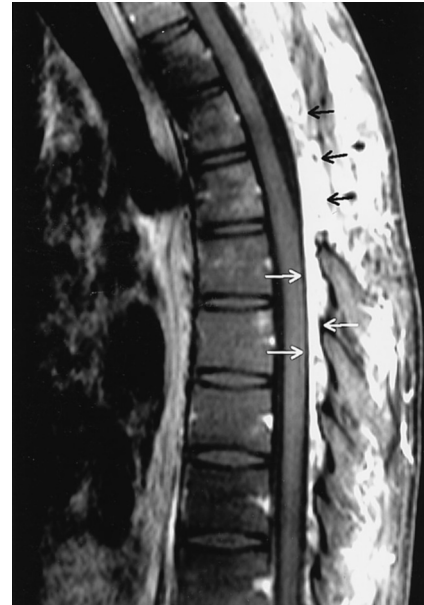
After chemotherapy, the sagittal T1W postcontrast MR image clearly documented the disappearance of the spinal solid mass (white arrows) under the laminectomy defect (black arrows).
